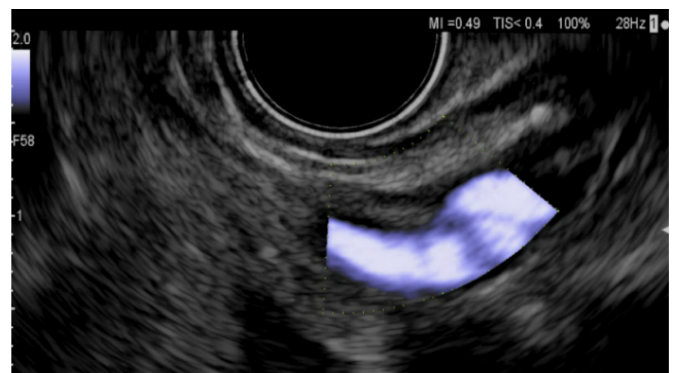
Feeding vessel identified using colour Doppler imaging.
